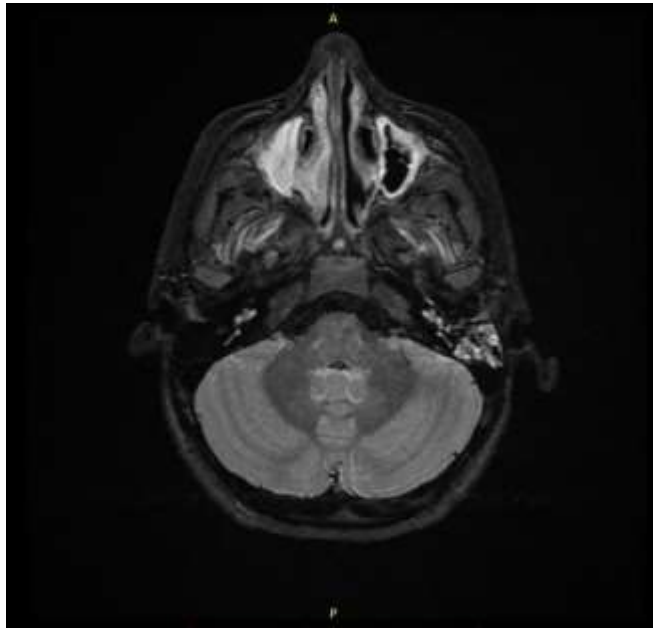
Axial MRI mastoid STIR (Thin) image for patient number 31 shows left mastoiditis, otitis, sinusitis.
